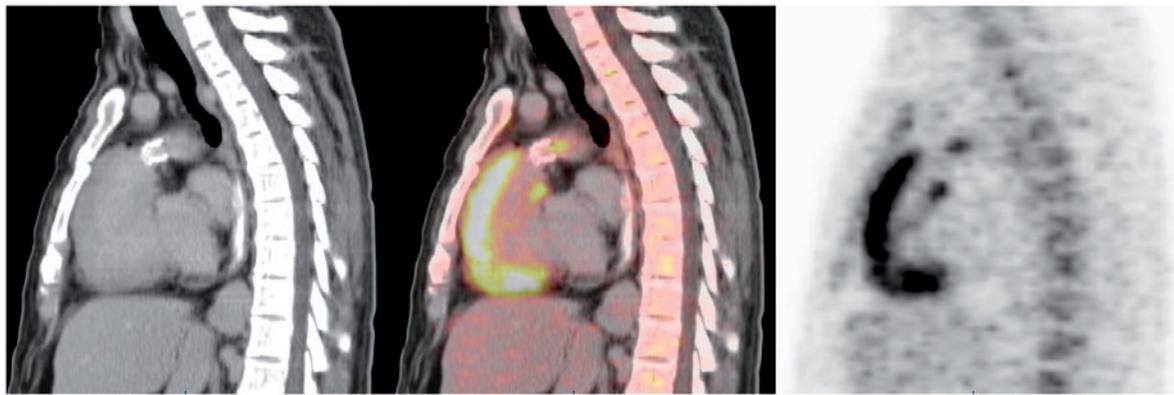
A 20-year-old man underwent a correction of transposition of great arteries during childhood with stent insertion in the pulmonary artery. He was hospitalized due to 4 weeks of fever. Methicillin-sensitive *Staphylococcus aureus* was cultured from the blood, antibiotic was started and trans-esophageal echocardiogram demonstrated pulmonary trunk stenosis with a suspicious echogenic mass within the pulmonary stent. PET/CT demonstrated pathological FDG uptake surrounding the pulmonary artery stent. In addition to 6 weeks of intravenous antibiotics, he underwent surgery with removal of the infected stent.
